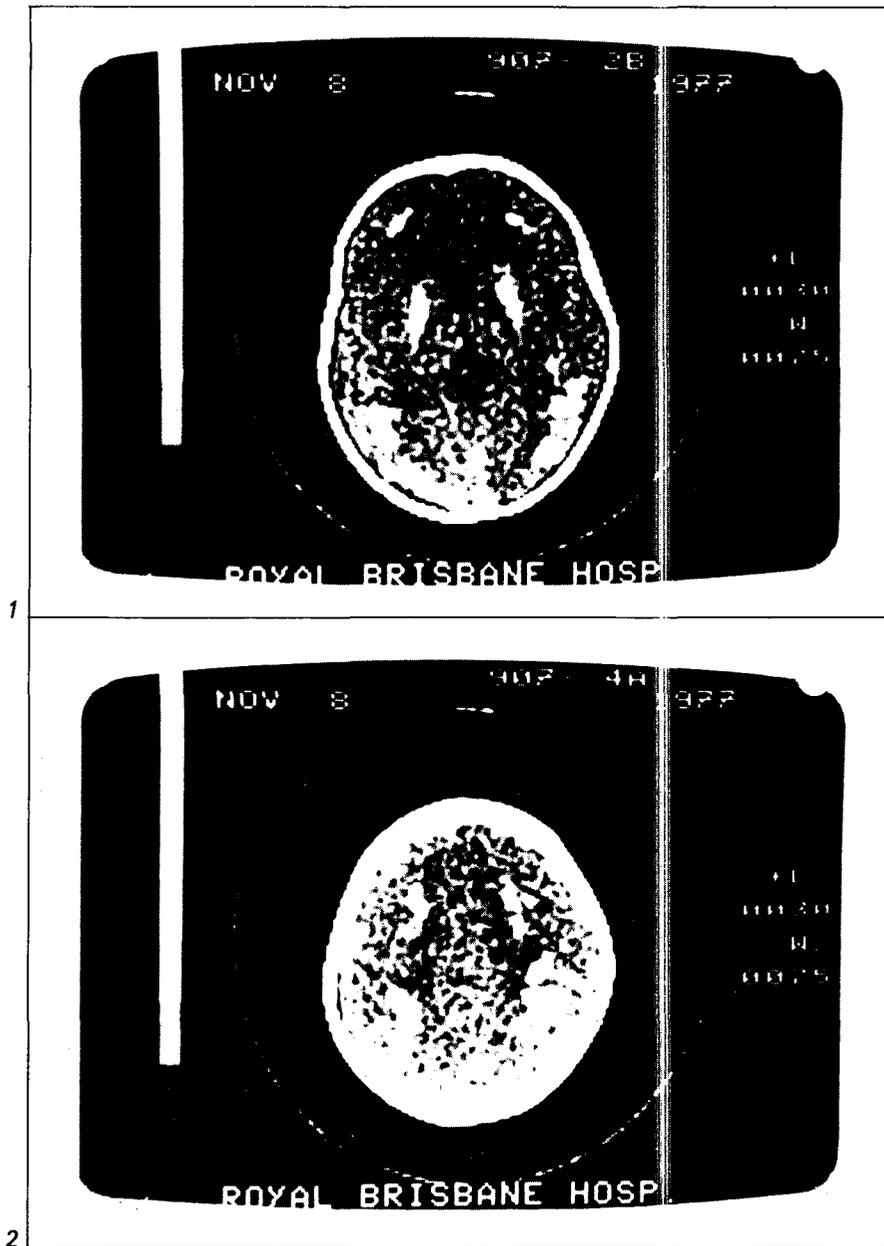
Patient FH. CT scan without contrast. Extensive periventricular calcification.
